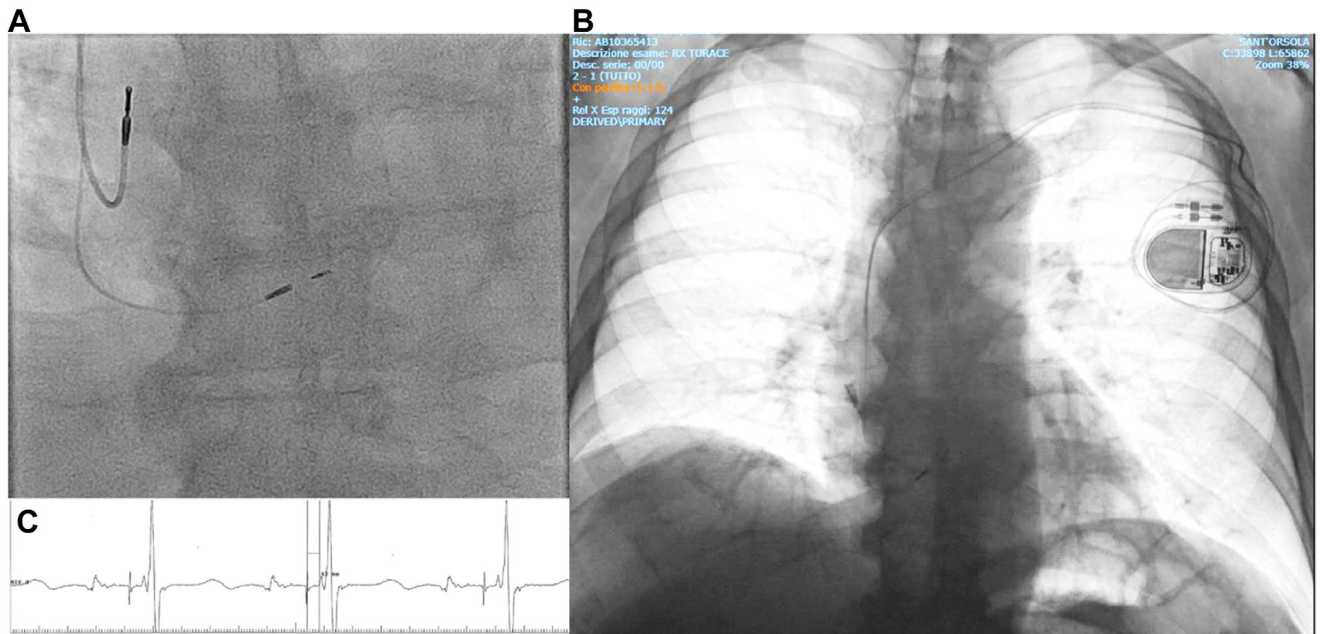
A: Fluoroscopic and B: chest radiograph view of the HB lead after implantation. C: The intracardiac electrogram from the HB lead before fixation shows prolonged AH interval (170 msec) with normal infranodal conduction (HV, 42 msec).
